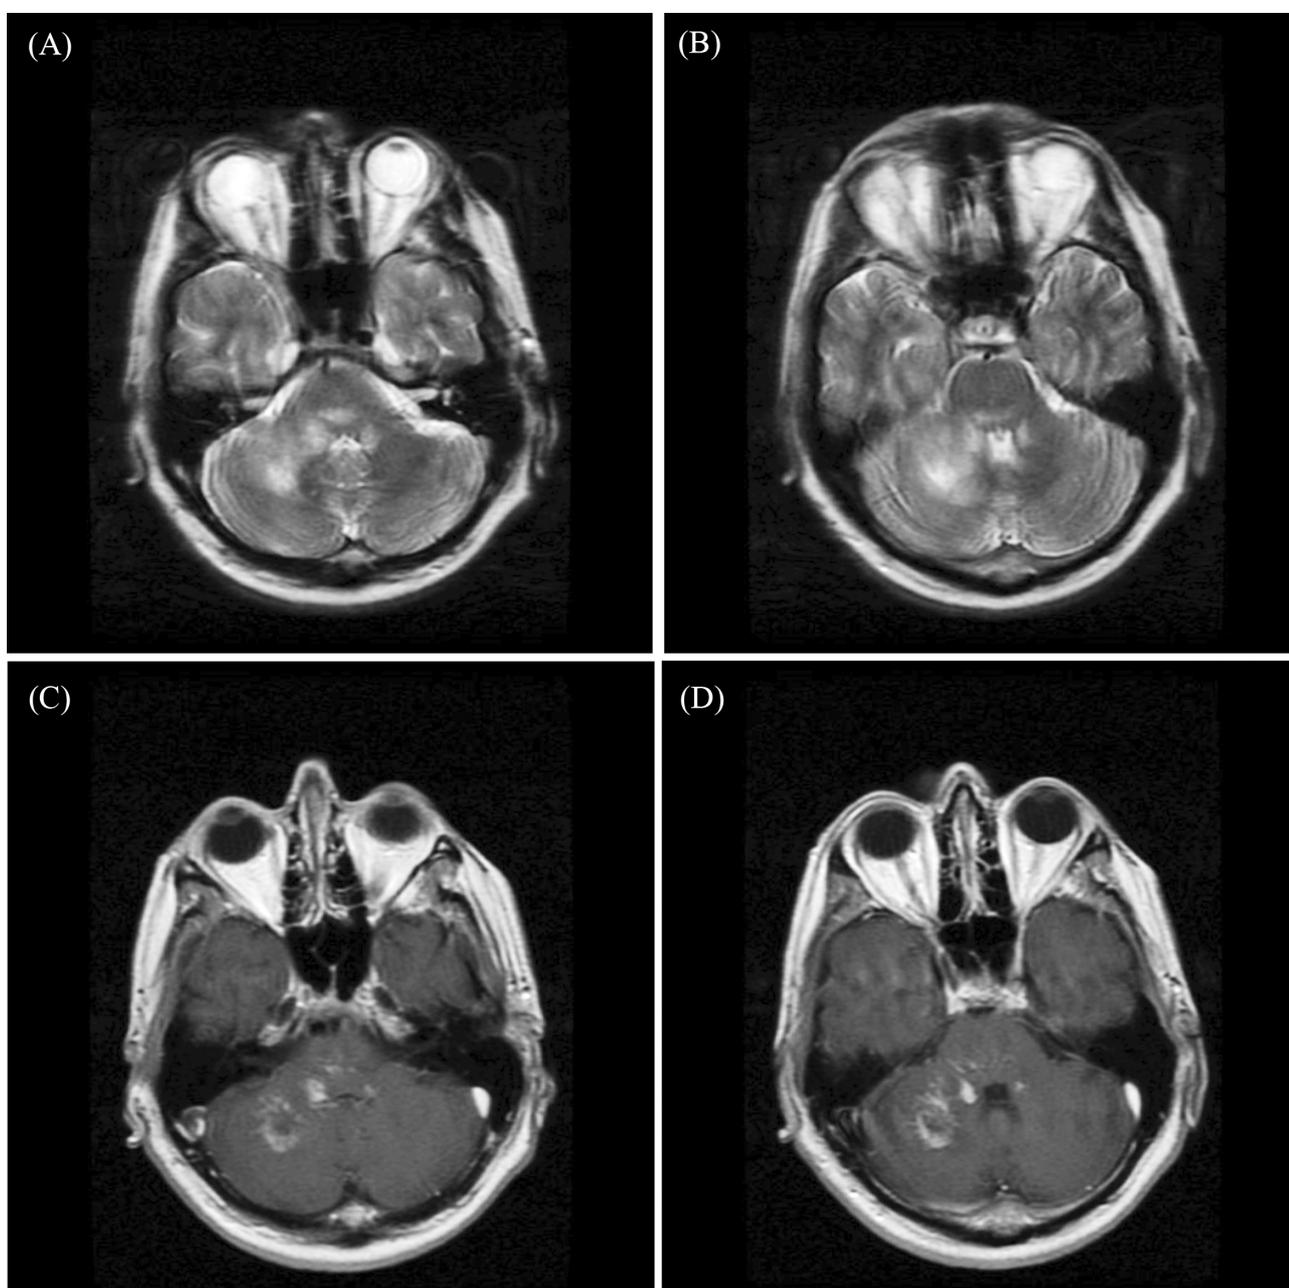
Conventional brain MRI shows pontine and cerebellar patchy T2-hyperintense (A & B) areas associated with punctuate and curvilinear contrast-enhancement in T1-weighted images (C & D).
